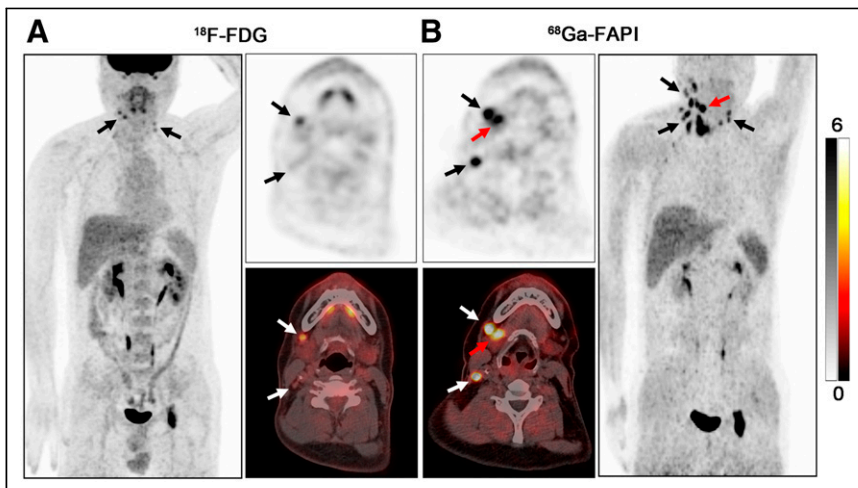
PET/CT scans with ^{18}F -FDG (A) and ^{68}Ga -FAPI (B) in a 41-y-old male patient (patient 5) with metastatic adenocarcinoma of right neck. ^{18}F -FDG PET/CT was negative for detection of primary. On ^{68}Ga -FAPI PET/CT, there was intensive uptake in right submandibular gland (B, red arrow; $\text{SUV}_{\text{max}} = 15.80$), whereas low background uptake was seen in left submandibular gland (SUV_{max} ratio = 6.87). Subsequent surgery confirmed salivary ductal carcinoma. Black and white arrows indicate metastatic lymph nodes.
